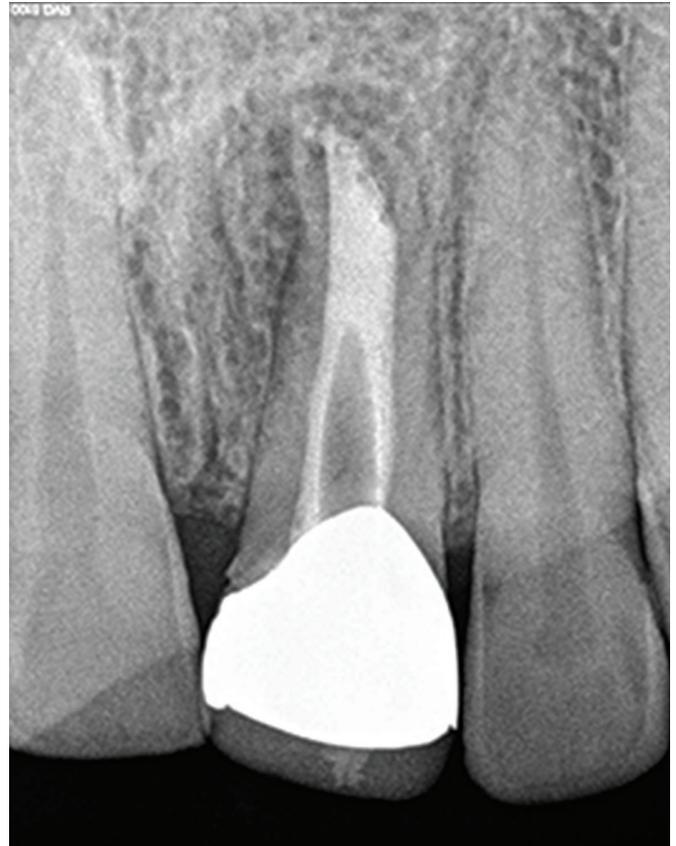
Three-month radiograph
